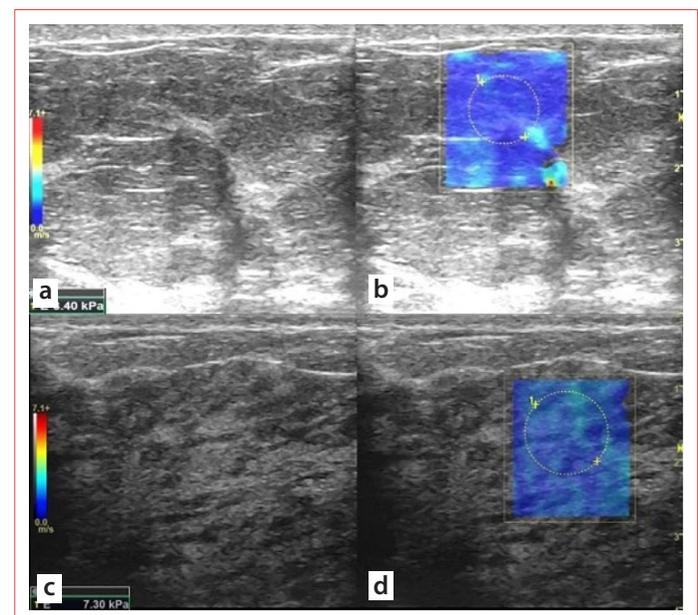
Representative images from two of our cases. The upper images (a and b) belong to a 55-year-old female patient and demonstrate the measurement obtained from the fatty parenchymal area. Grayscale ultrasonography image (a) and shear-wave elastography (SWE) image (b) are shown. In the SWE image (b), the region of interest (ROI) used for stiffness measurement is marked, and the measurement was performed from the upper outer quadrant of the breast. The lower images (c and d) belong to a 33-year-old female patient and similarly show the grayscale US image (c) and the SWE image (d). In the SWE image (d), the ROI used for stiffness measurement is marked, and the measurement was also performed from the upper outer quadrant of the breast. The quantitative stiffness value in kilopascals (kPa) is displayed in the lower left corner of the images.
